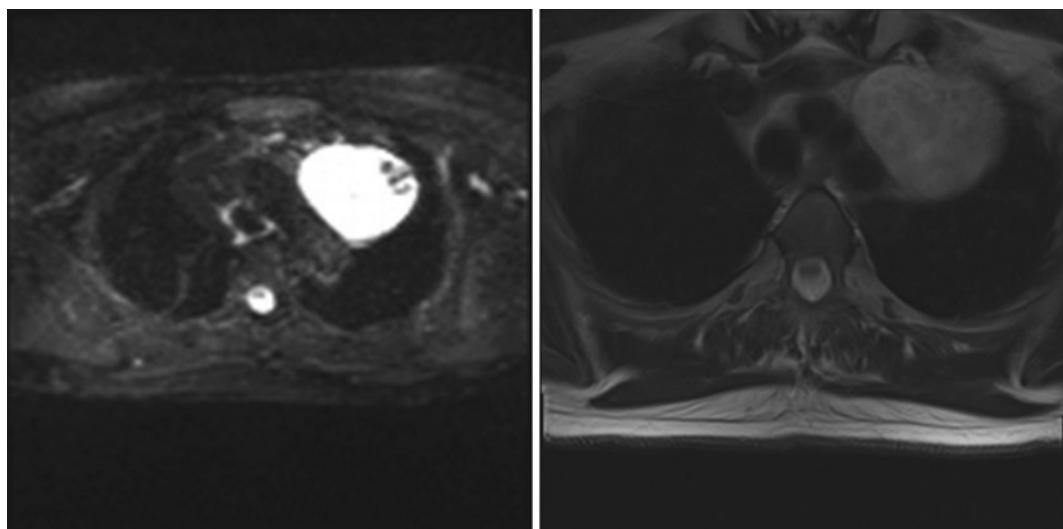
A magnetic resonance imaging (MRI) of the chest. This patient has a diagnosis of Schwannoma.
